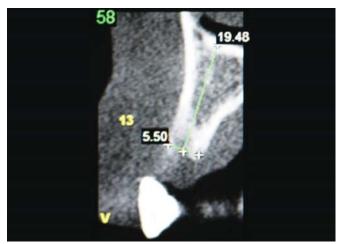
CT scan showing complete restoration of the vestibular bone crest and total healing of the alveolar bone
